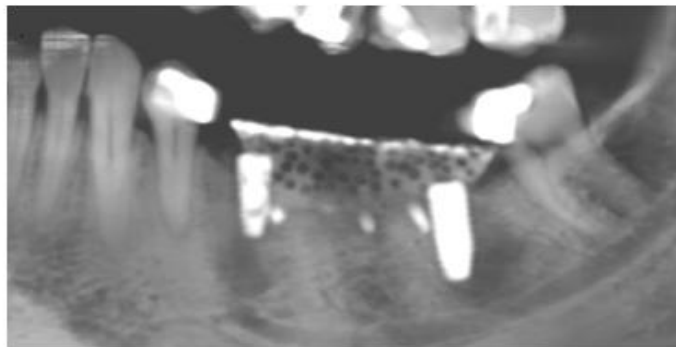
post-operative CBCT showing mesh in place
